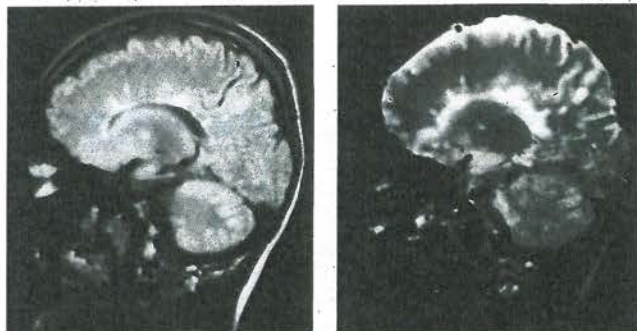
Sagittal MRI scan showing periventricular plaques of demyelination. Left: T1-weighted; right: T2-weighted
